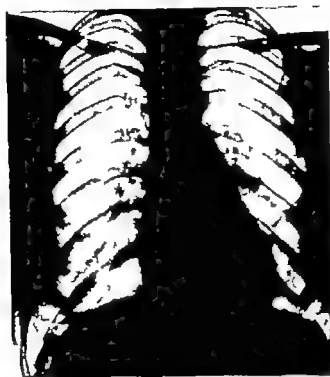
10—Mass radiography of symptomless tumour near left hilum.
